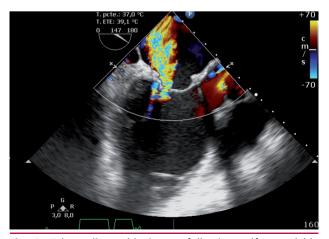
Echocardiographic image following self-expandable valve implantation.
